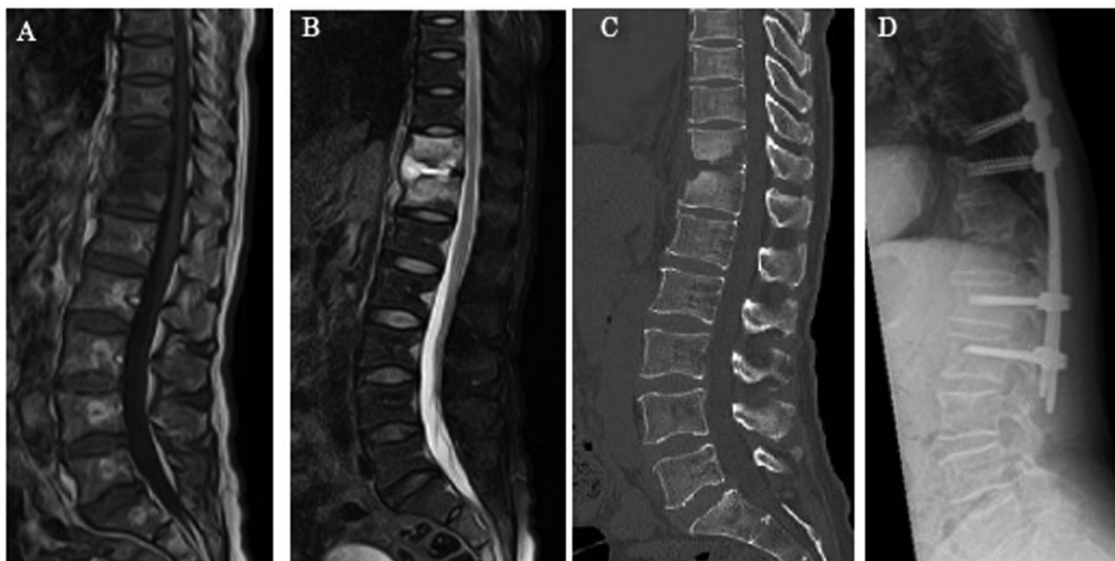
Radiological findings in a case of pyogenic spondylitis in which posterior fixation was performed because spinal instability was recognized. (A) T2-weighted, fat-suppressed sagittal magnetic resonance image showing hyperintense signals at Th11/12, suggestive of pyogenic spondylitis. (B) Computed tomography demonstrating destructive change at the Th11/12 level. (C) Lateral radiograph after percutaneous posterior (D) fixation from T9 to L2.
